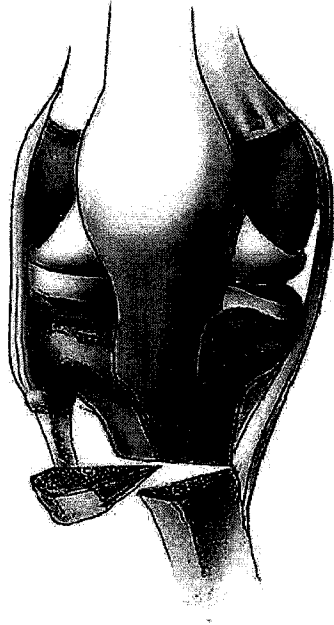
If significant internal tibial torsion is present, the distal fragment is externally rotated prior to removal of the laterally based wedge. The thickness of the wedge is determined using a template drawn from the preoperative radiograph.
